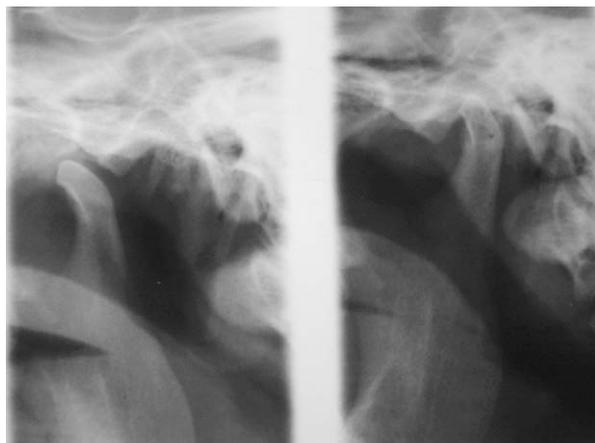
Pre-operative x-ray reveal anterior dislocation of the condyle when mouth was open (Patient No: 1).
